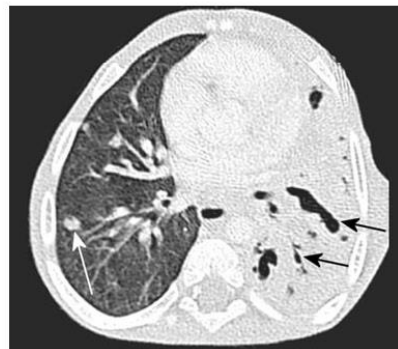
Contrast-enhanced axial chest CT of a 10-month-old boy with lymphobronchial TB demonstrates bronchiectasis (*black arrows*) within the consolidated left lung distal to a focal compression of left main bronchus (not shown). An ovoid nodule is seen in the right lung (*white arrow*)
